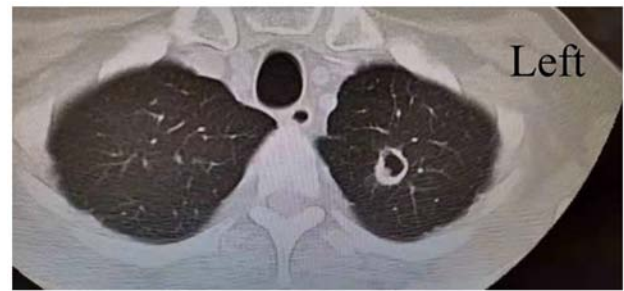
Lung computed tomography of the patient described in the present study.
